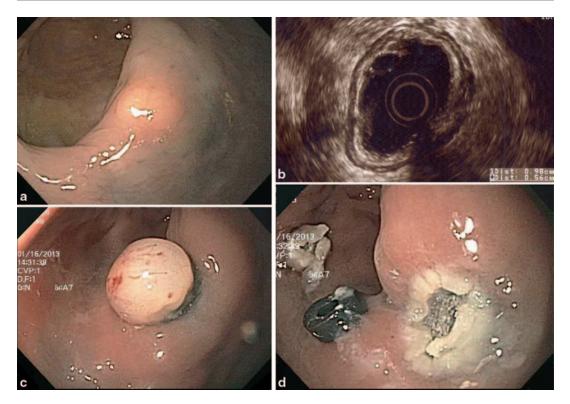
Duodenal carcinoid tumor. a Endoscopic appearance of a carcinoid in the duodenal bulb, demonstrating a central depression. b Endosonographic appearance
